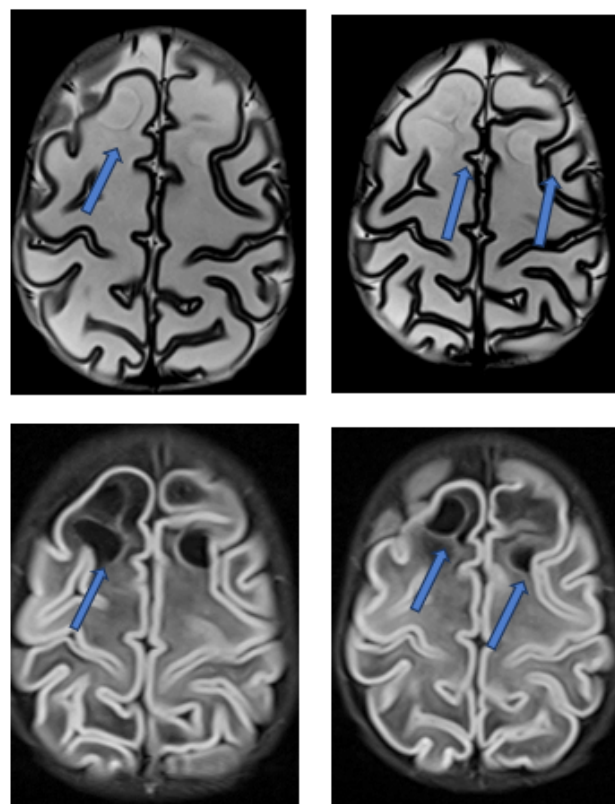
MRI axial sections in T2-weighted (a and b) and FLAIR-weighted (c and d) sequences. Bilateral frontal subcortical cysts (arrows) in T2 hypersignal and FLAIR hyposignal.
